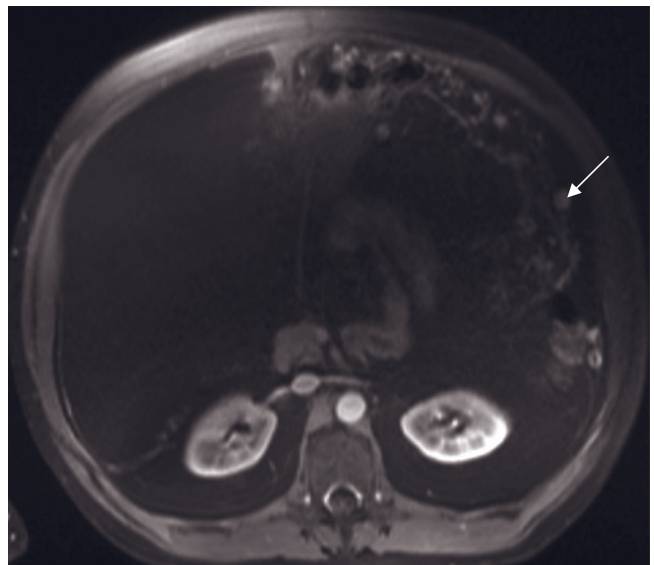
Omental metastases. Transverse gadolinium-enhanced T1-weighted fat-suppressed spin-echo images in a patient with metastatic ovarian carcinoma (a) and metastatic leiomyosarcoma (b). The enhancing “omental cake” (arrowheads, a, b) is characteristic of metastatic ovarian carcinoma, but also may be seen with other malignant diseases. Enhancing peritoneal tumor deposits (arrow, a) are rendered very conspicuous with suppression of background fat. MRI is superior to CT imaging in detecting small peritoneum-based disease. Interstitial-phase gadolinium-enhanced fat-suppressed T1-weighted SGE images (c-e) in a third patient with adenocarcinoma demonstrate similar findings. The peritoneum is thickened and enhances intensely (arrows, c, d). T1-weighted fat-suppressed interstitial-phase postgadolinium 3D-GE images (f-i) in another patient show multiple omental metastases (white arrows), and thin platelike and small nodular peritoneal metastases (black arrow, g).
